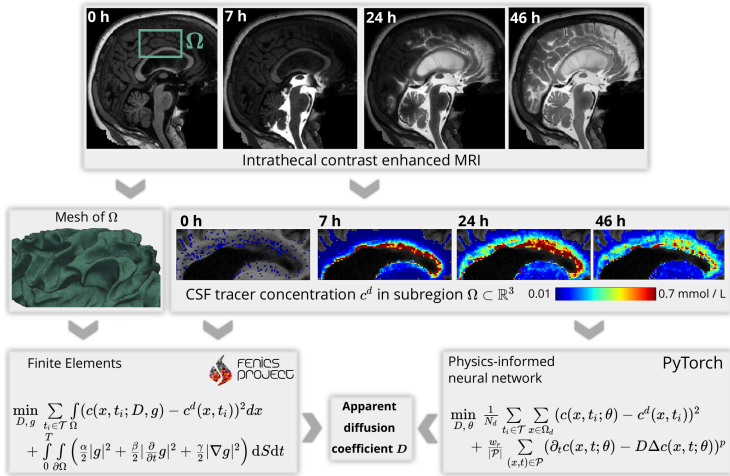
Graphical summary of Paper I. We compare PINNs to a FEM based approach for estimating the apparent diffusion coefficient describing the distribution of CSF tracer seen in MRI.
